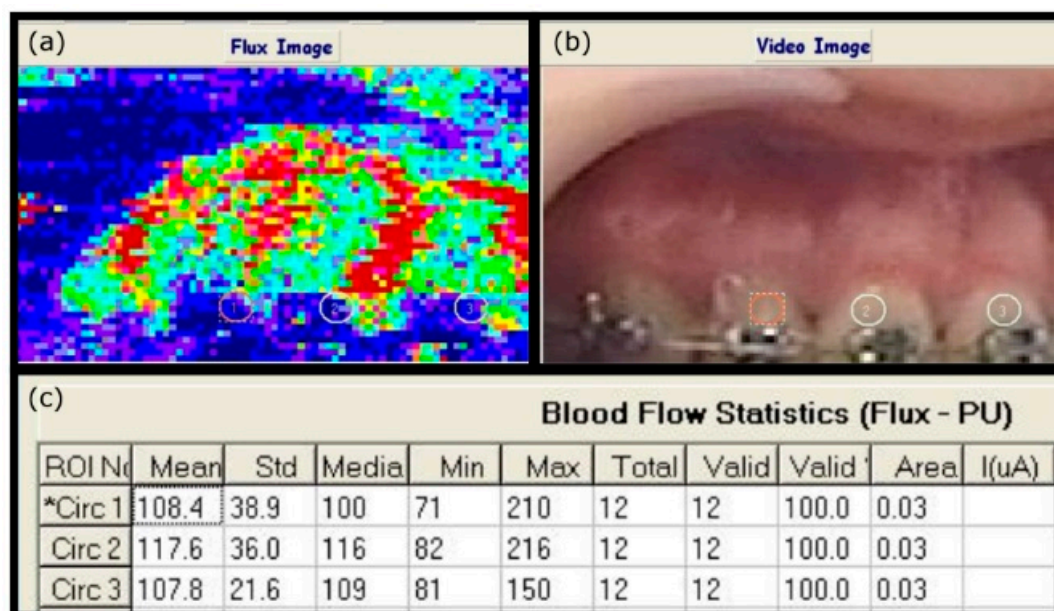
Laser Doppler to track the pulp vitality. (a) In the flux image, the red color represents areas of abundant blood flow, corresponding to the video image (b), in which the red circle shows the tooth to be measured. According to (c), PU analysis of laser Doppler revealed that circle 1 was the red circle (* means the circle 1 was selected as the reference). The calculated perfusion units in the diseased tooth were not significantly different from those in the two control teeth, indicating that the tooth remained viable. Continuous follow-up was recommended.
